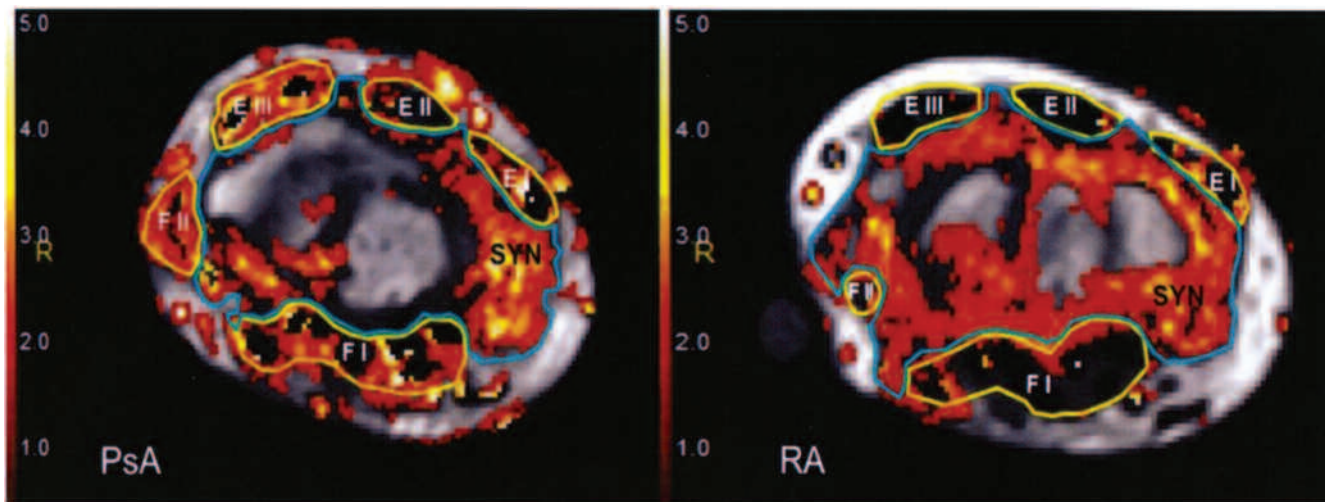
Representative parametric maps of dynamic, contrast-enhanced magnetic resonance imaging (MRI) data of maximum enhancement superimposed on an axial T1-weighted dynamic MRI of the wrist in a patient with psoriatic arthritis (PsA) and another patient with rheumatoid arthritis (RA). The region of interest containing the wrist synovial membrane is outlined in light blue; regions around the tendon sheaths are yellow. The different synovial compartments evaluated are outlined (SYN = joint synovial membrane; EI-III = first to third extensor compartment; FI-II = first and second flexor compartment). In this example, tenosynovitis prevails in PsA and joint synovitis in RA.
